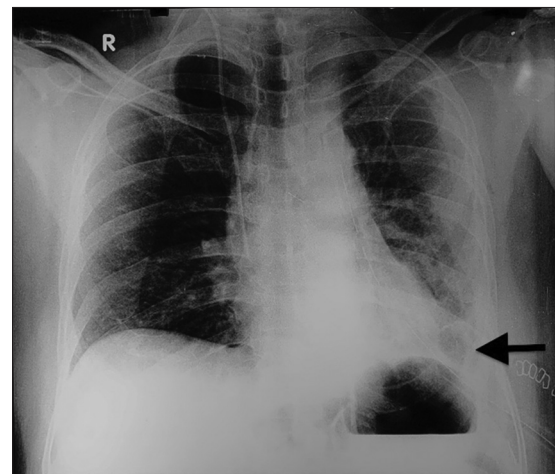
Chest X-ray posteroanterior view on post-operative day 5 shows significant radiological improvement (black arrow)
